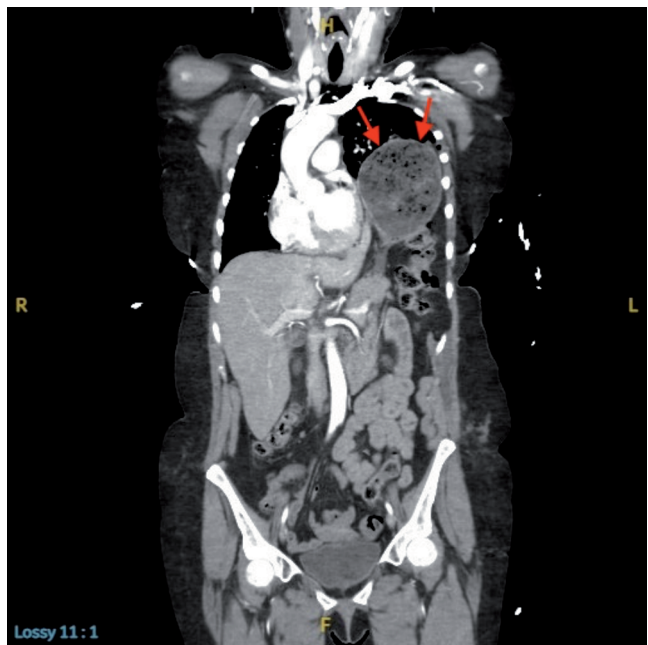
Patient 2: CT scan of the chest, abdomen, and pelvis showing diaphragm injury and herniation of the spleen, stomach, lobe of liver, and left colon (red arrows indicate area of herniation).
